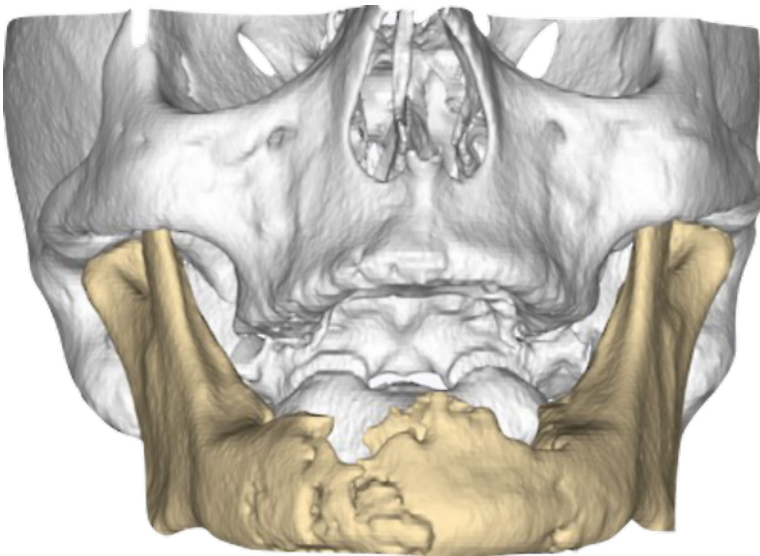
3D reconstruction from the final CT scan; proof of severe osteolysis of the mandible with a high risk of a pathological fracture.
